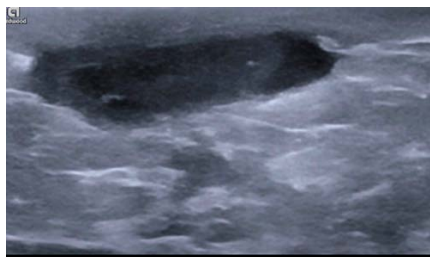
Targeted ultrasound of the left subareolar area showed a complex fluid collection measuring $0.9 \times 3.5 \times 0.9$ cm, suggestive of an abscess.
